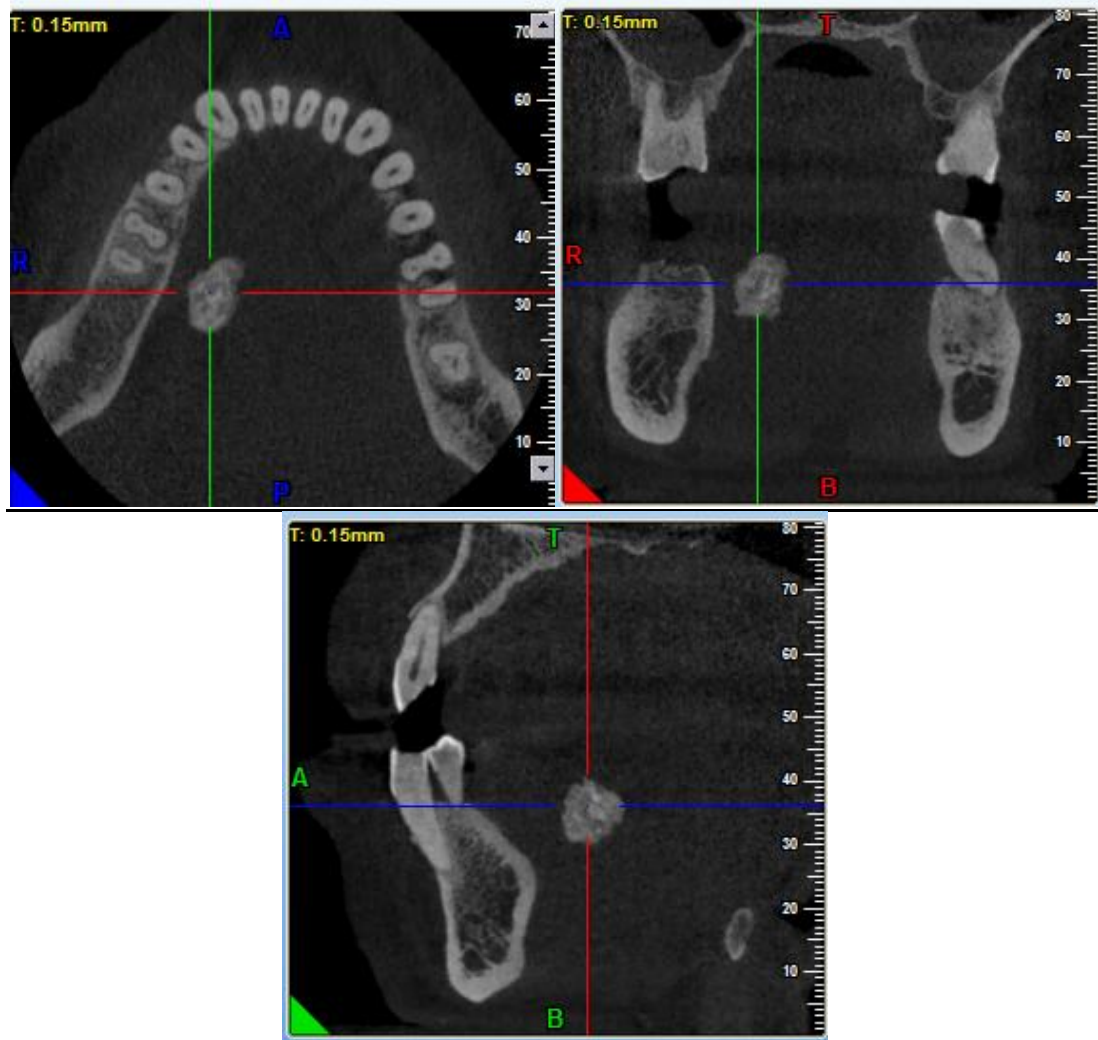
Pre-operative image of sialolith in CBCT scan seen in (a) Axial section (b) Coronal section (c) Sagittal section
